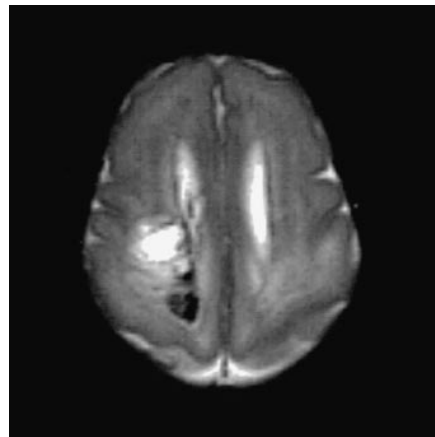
Postmortem T2-weighted (3500/208) FSE sequence in preterm infant of 2 weeks' (+5 days) gestation (case 4) shows bilateral abnormal signal intensity within the posterior periventricular white matter and a low signal intensity hemorrhagic component on the right.
